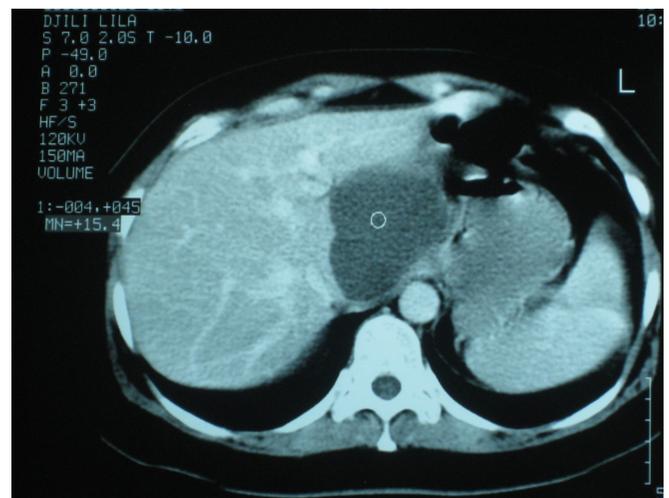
Post-operative bilomas in CT
